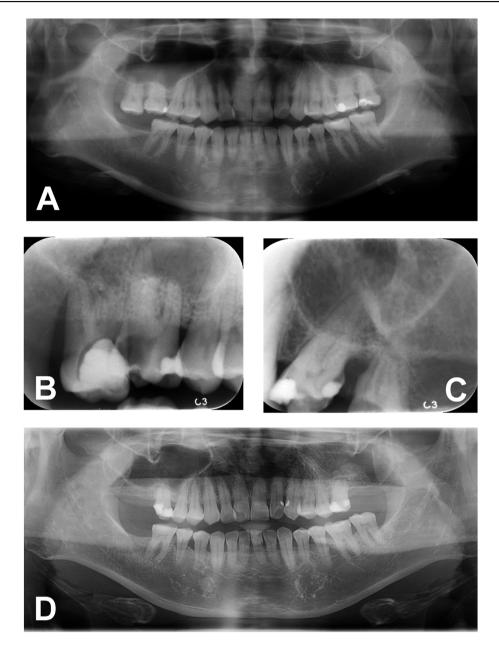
Panoramic and periapical radiographs of a long-term oral health care for a human immunodeficiency virus-infected patient under the coverage of Taiwan's National Health Insurance system. (A) Original panoramic radiograph of September 24, 2014 revealing elongation of the tooth 17, decay with dislodged restoration of the teeth 26 and 27, missing of the tooth 47. (B) The tooth 17 was removed due to elongation with decay on September 29, 2021. (C) The tooth 27 was also extracted due to tooth fracture with decay on May 25, 2022. (D) The follow-up panoramic radiograph on November 22, 2023 showing normal occlusal function from the anterior teeth to the first molar.
